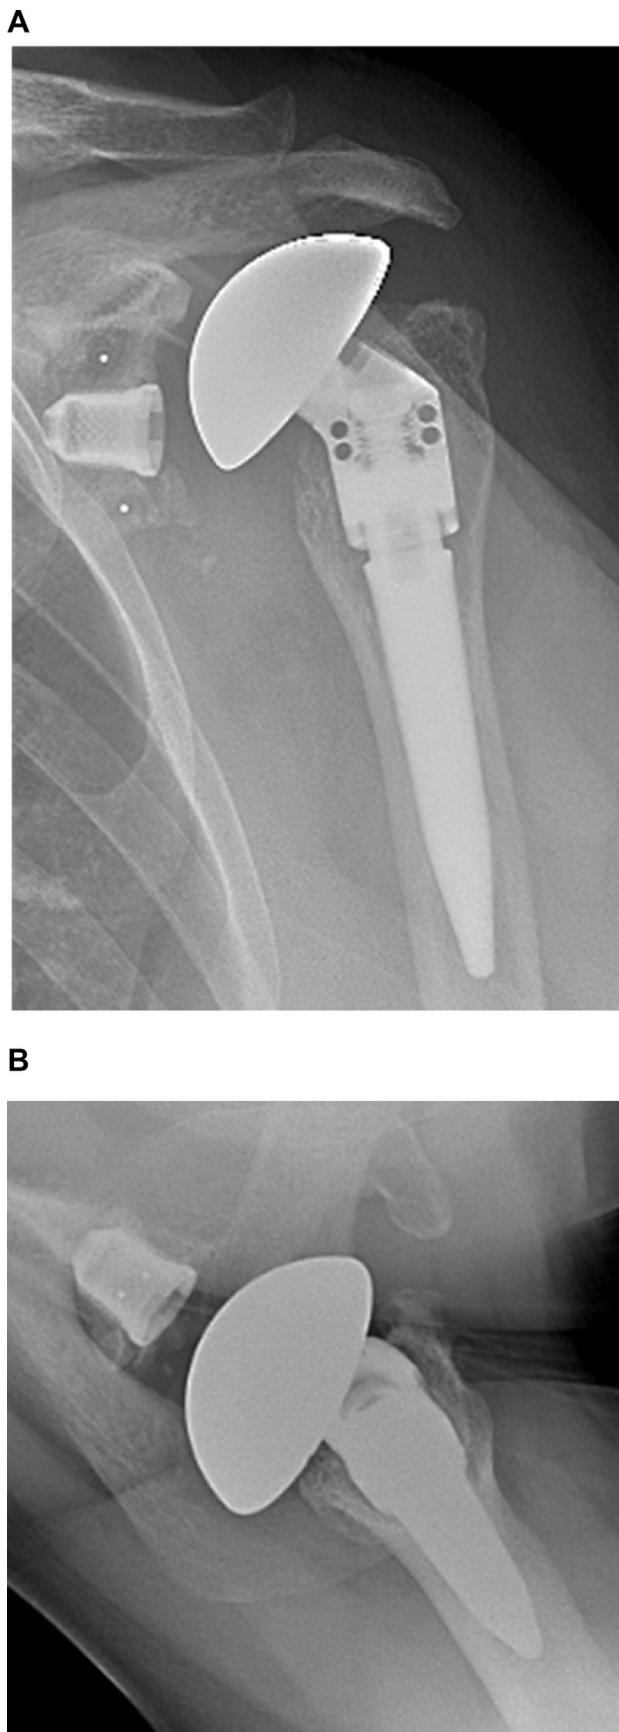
(A) Anteroposterior and (B) axillary radiographs of the left shoulder after a traumatic fall causing an acute injury to the rotator cuff leading to anterosuperior migration of the humeral component compared with previous imaging.
